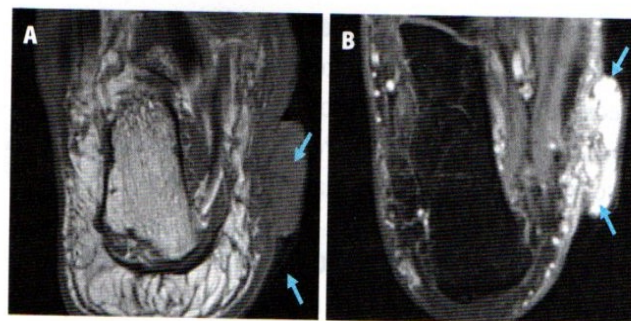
Epidemic KS on magnetic resonance (MR) images of the foot. Coronal T1-weighted (A) and postcontrast T1-weighted fat-saturated (B) images of the foot showing an exophytic lesion (abnormal growth extending from the surface of tissue), low signal on T1-weighted image with avid enhancement and a nodular proliferation of the dermis (arrows). Reprinted under the Creative Commons Attribution 4.0 International License. Hughes P, Miranda R, Doyle AJ. MRI imaging of soft tissue tumours of the foot and ankle. *Insights Imaging*. 2019;10(60). doi:10.1186/s13244-019-0749-z. creativecommons.org/licenses/by/4.0/
